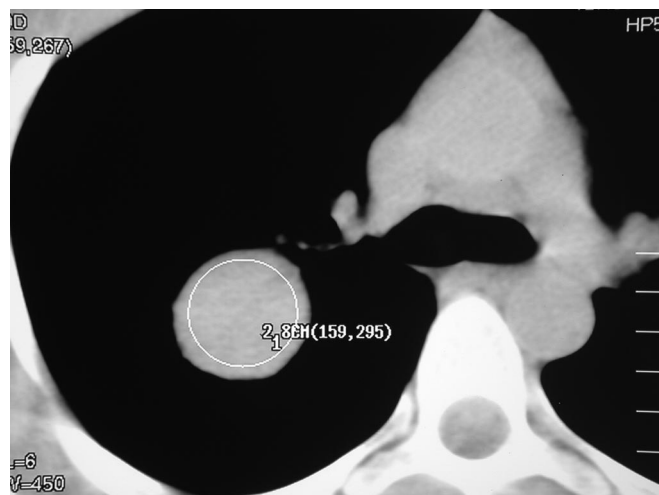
The chest computed tomographic scan shows a homogeneous well-defined perihilar mass without calcification in the right upper lobe.
